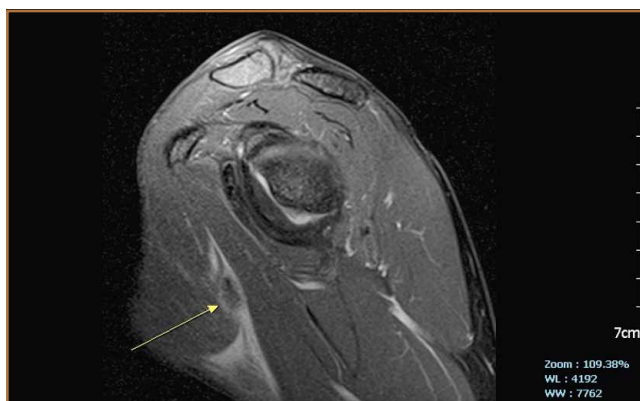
Sagittal right chest fat-suppressed proton-density magnetic resonance imaging. Long arrow points to the retracted pectoralis major muscle tendon.
